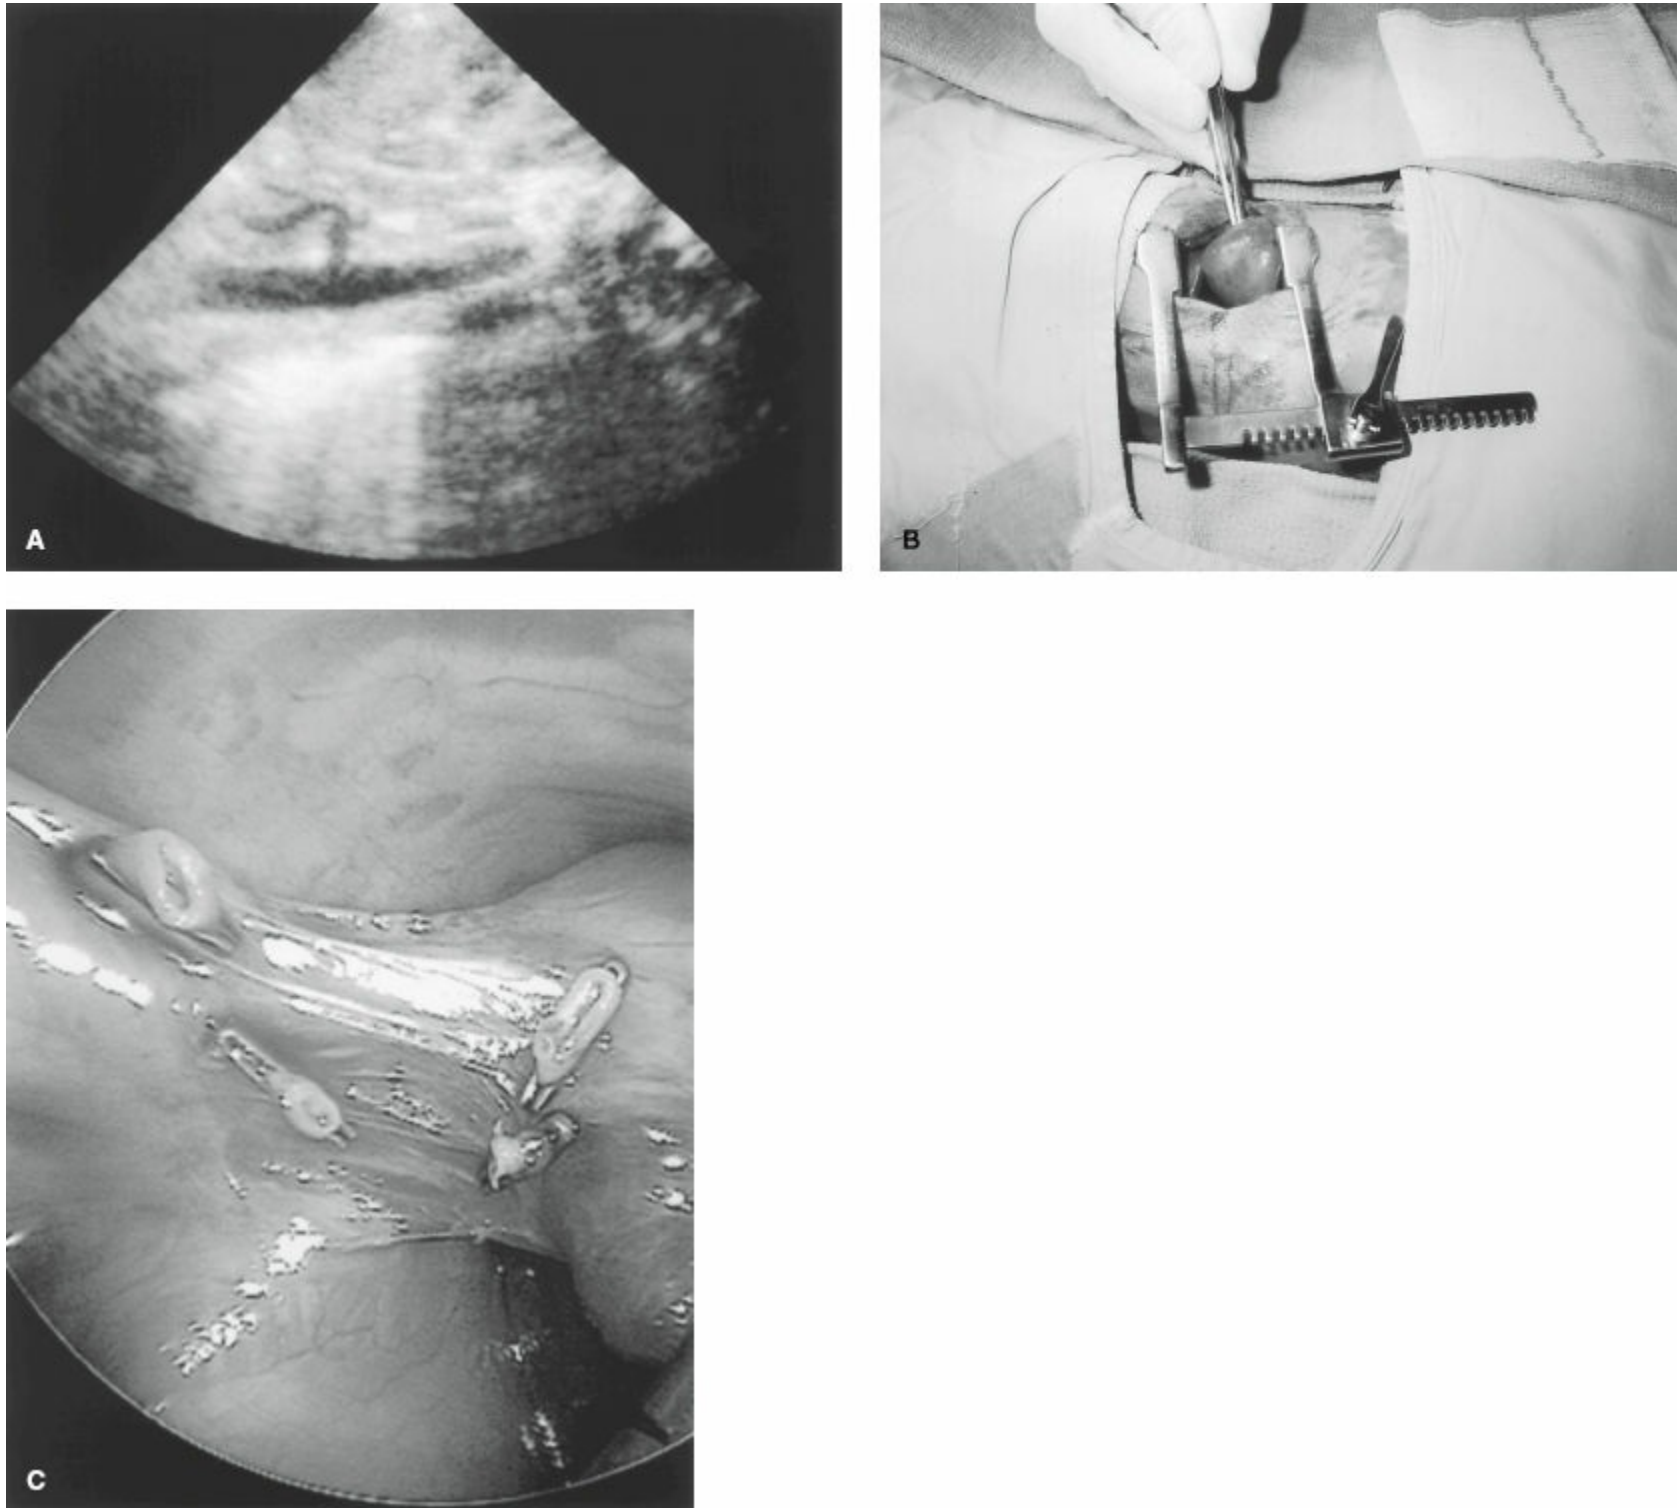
Pulmonary sequestration (PS). A: Sagittal ultrasound view of the aortic branch supplying an extralobar PS. B: Left-sided extralobar PS excised via a muscle-sparing thoracotomy. C: Intraoperative view of extralobar sequestration removed thoracoscopically. Note the main blood supply with clips.
